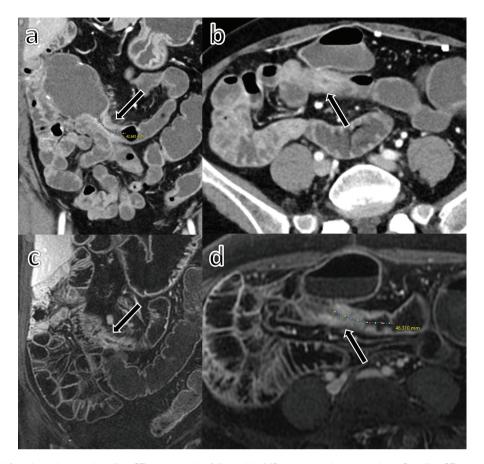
A 56-year-old female underwent baseline CT enterography followed by MR enterography 5 years later. Baseline CT enterography exam demonstrates an ileocecal resection with 4.3 cm of neo-terminal ileal inflammation and an EMBARK score of 2 (A, B: arrows). Follow-up MR enterography exam demonstrates similar length and severity of inflammation (4.6 cm, EMBARK score 2, C, D: arrows), indicating stable disease by predefined response criteria.
